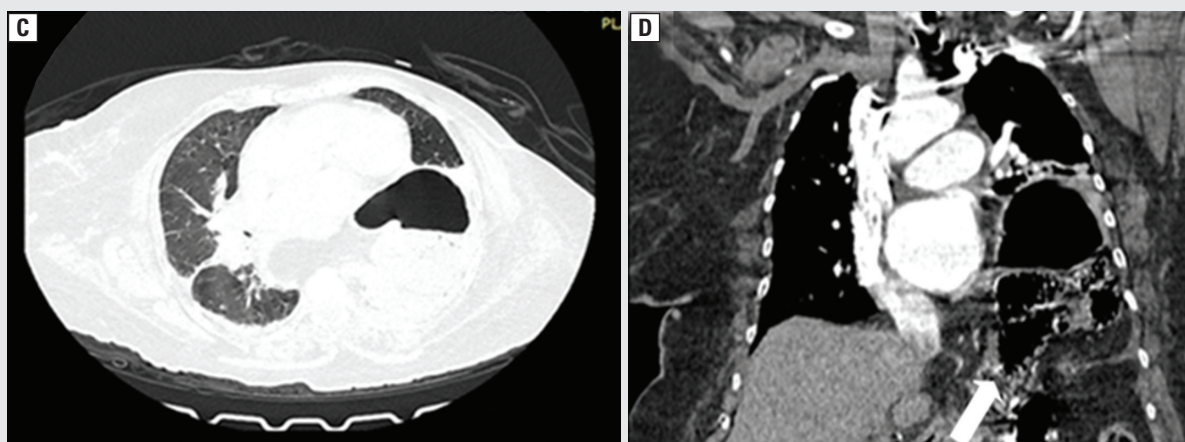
Computed tomography (CT) pulmonary window axial section showing an air-fluid level in the left hemithorax; D. CT mediastinal window coronal section white arrow showing a defect in the left hemidiaphragm with herniation of the stomach and bowel loops into the left hemithorax, and a mediastinal shift towards the right side
